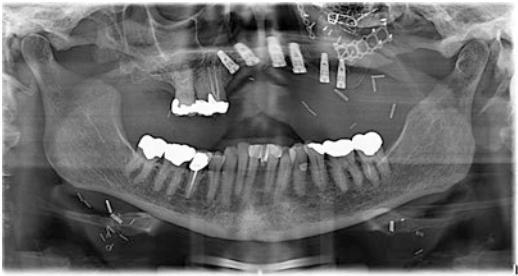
Panoramic radiograph showing implants placed within scapula flap reconstruction of Brown and Shaw Class IV maxillectomy
